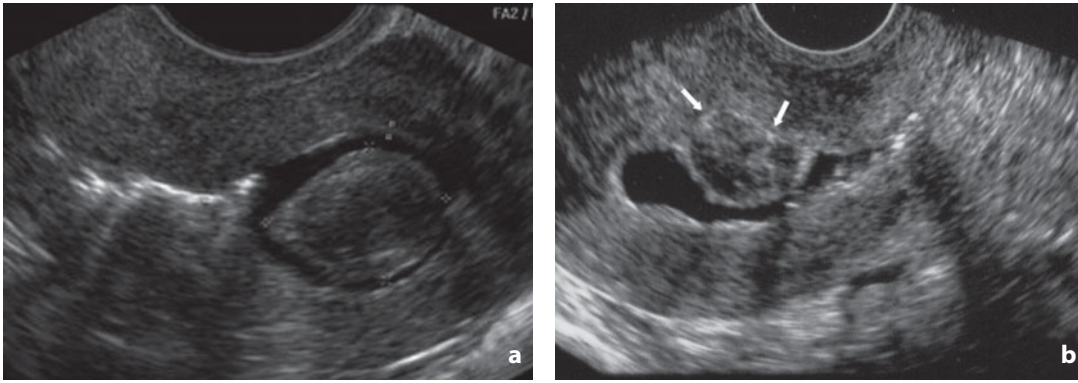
Hysterosonography. Submucosal leiomyoma. a The lesion bounded by crosses projects into the endometrial cavity. It appears hypoechoic with echotexture similar to the myometrium. b Different case. The lesion (*arrows*) projects into the uterine cavity by more than 50%
